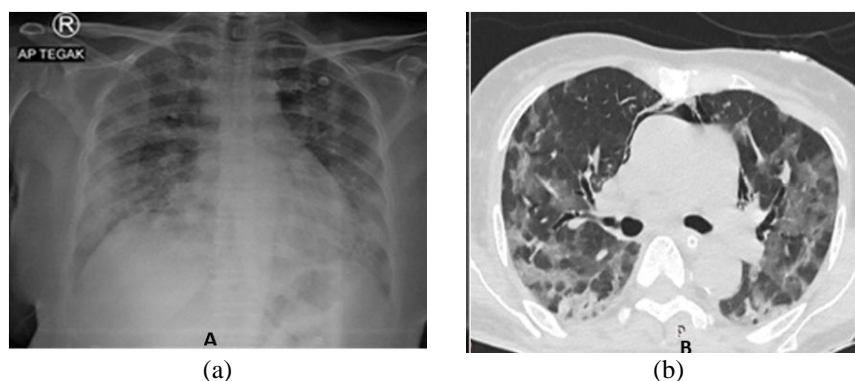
Radiological imaging of the female patient's chest: (a) X-ray and (b) axial CT scan
